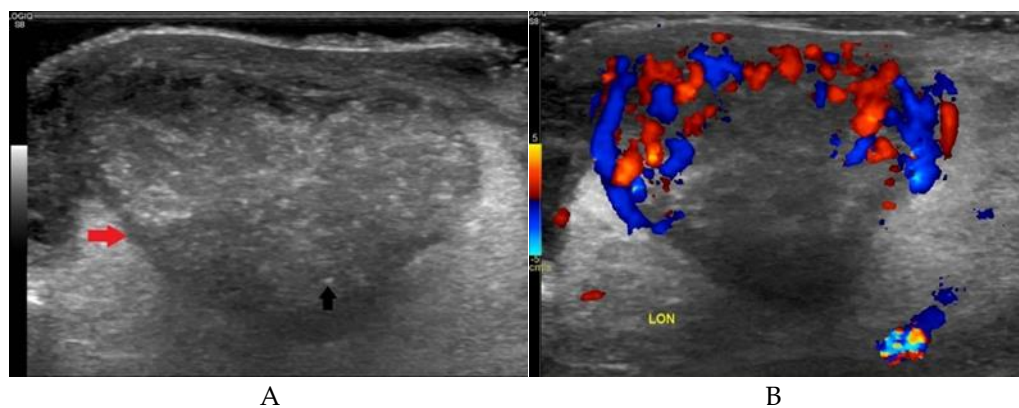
Ultrasound findings. A: Heterogeneous content with punctate calcifications (black arrows) and hypoechoic ring (red arrow); B: Color Doppler shows peripheral vascularity.
